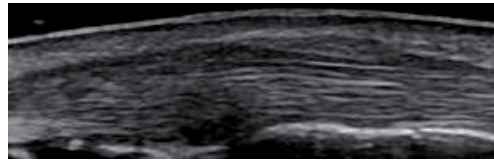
Thick edematous tendon of APL muscle in longitudinal ultrasound image of a patient with De Quervain tenosynovitis.
